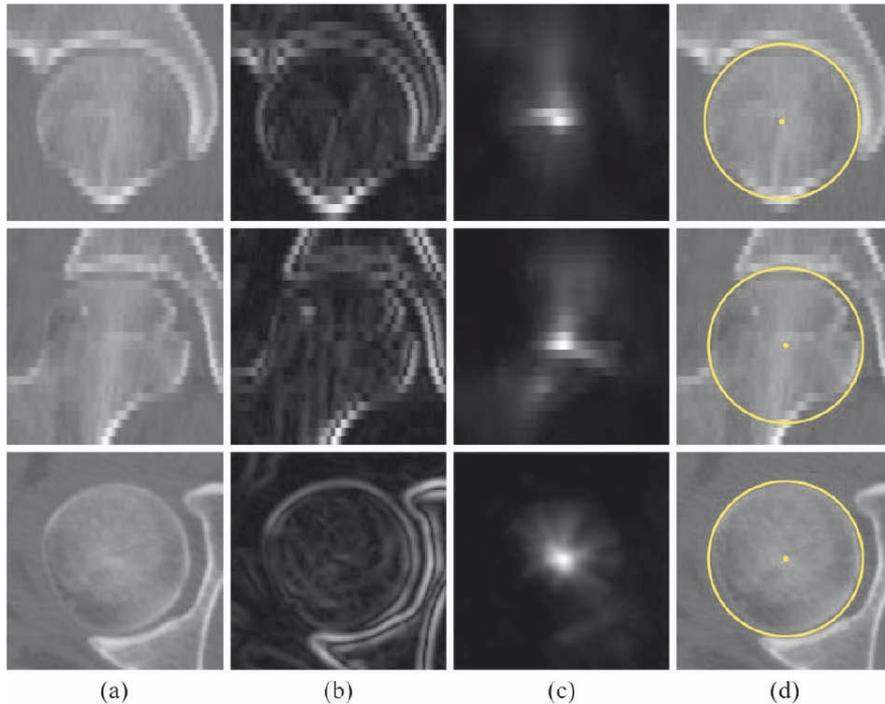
The determination of the exact center and size of the left femoral head in 3-D, shown in its mid-sagittal (*top*), mid-coronal (*middle*) and mid-axial (*bottom*) CT cross-section as (a) original images, (b) magnitudes of image intensity gradient vectors, (c) accumulator images of lines in the direction of image intensity gradient vectors, and (d) original images with the obtained center and size of the femoral head.
